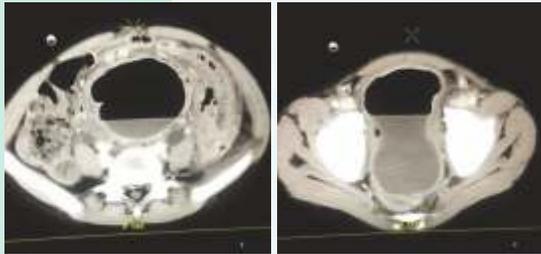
CT Abdomen showing uniloculated cavity with air-fluid level extending from pelvis to abdominal cavity suggestive of an intraperitoneal abscess.
